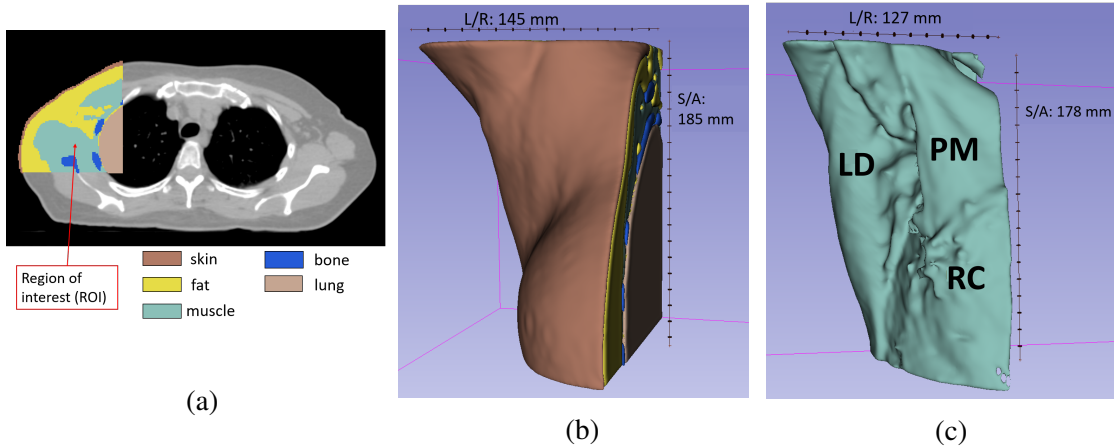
In (a), image of the axial view of the body (XY-plane in Fig. 4.1) at the level of the sternum: the segmented organs are shown on top of the original CT. Each tissue is represented by a different color as detailed in the legend. The red arrow points at the segmented region of interest. In (b), 3D-rendering view in 3D-slicer of the segmented organs. In (c), 3D-rendering view in 3D-slicer of the segmented muscle tissue. Different muscles of the region are indicated: pectoralis major (PM), latissimus dorsi (LD), and rib-cage (RC) muscle. The pectoralis minor (i.e., the fourth muscle belonging to the axillary region) is not visible due to the frontal perspective of the figure. Superior/Anterior (S/A) and Left/Right (L/R) dimensions of the model are reported.
